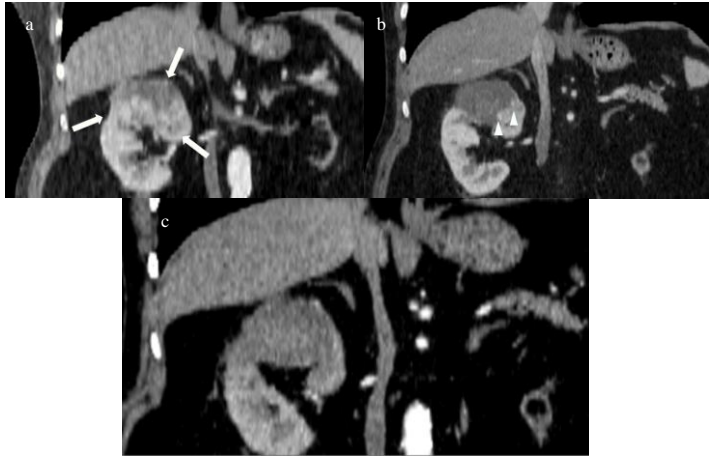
a. Preoperative coronal CT image shows endophytic contrast enhanced mass (Arrows), RCC b. Postoperative 12. Month postcontrast coronal CT image shows nodular enhancement compatible with relapse (arrowheads). c. No enhancement is observed in the CT taken after the treatment of the recurrent lesion
